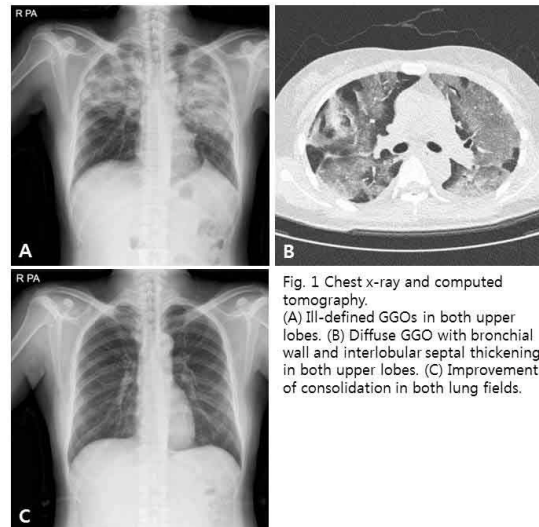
Chest x-ray and computed tomography. (A) III-defined GGOs in both upper lobes. (B) Diffuse GGO with bronchial wall and interlobular septal thickening in both upper lobes. (C) Improvement of consolidation in both lung fields.
